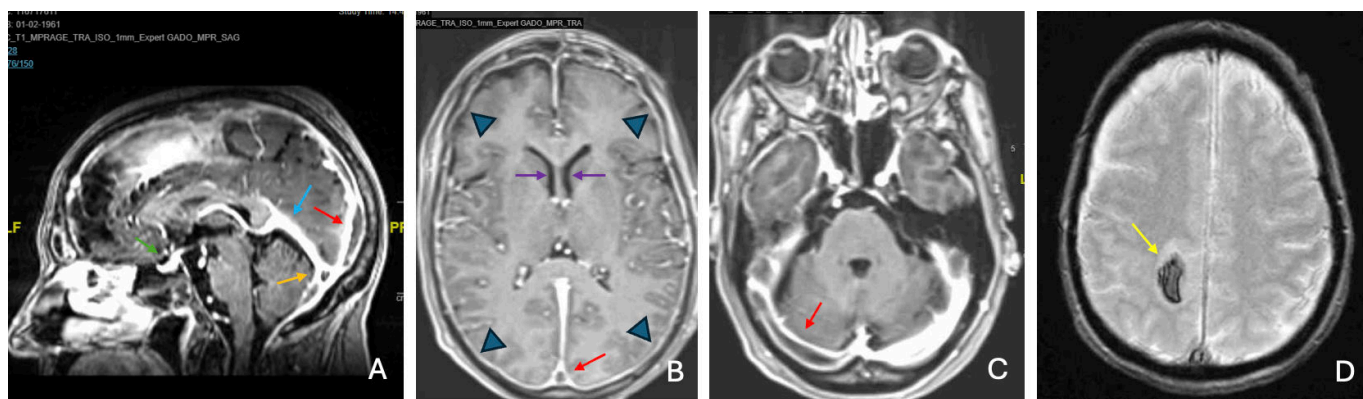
(A) Sagittal gadolinium-enhanced brain T1-weighted MRI showing superior sagittal sinus thrombosis (SSS) (red arrow) and torcular thrombosis (orange arrow), associated with signs of spontaneous intracranial hypotension, including engorgement of the straight sinus (blue arrow) and effacement of the suprasellar cistern (green arrow). (B) Axial gadolinium-enhanced brain T1-weighted MRI showing bilateral pachymeningeal enhancement (arrowheads), SSS thrombosis (red arrow), and reduced diameter of the lateral ventricles (purple arrows). (C) Right transverse venous sinus thrombosis (red arrow). (D) Hemorrhagic transformation of a right frontal parenchymal infarction due to cerebral venous sinus thrombosis.
